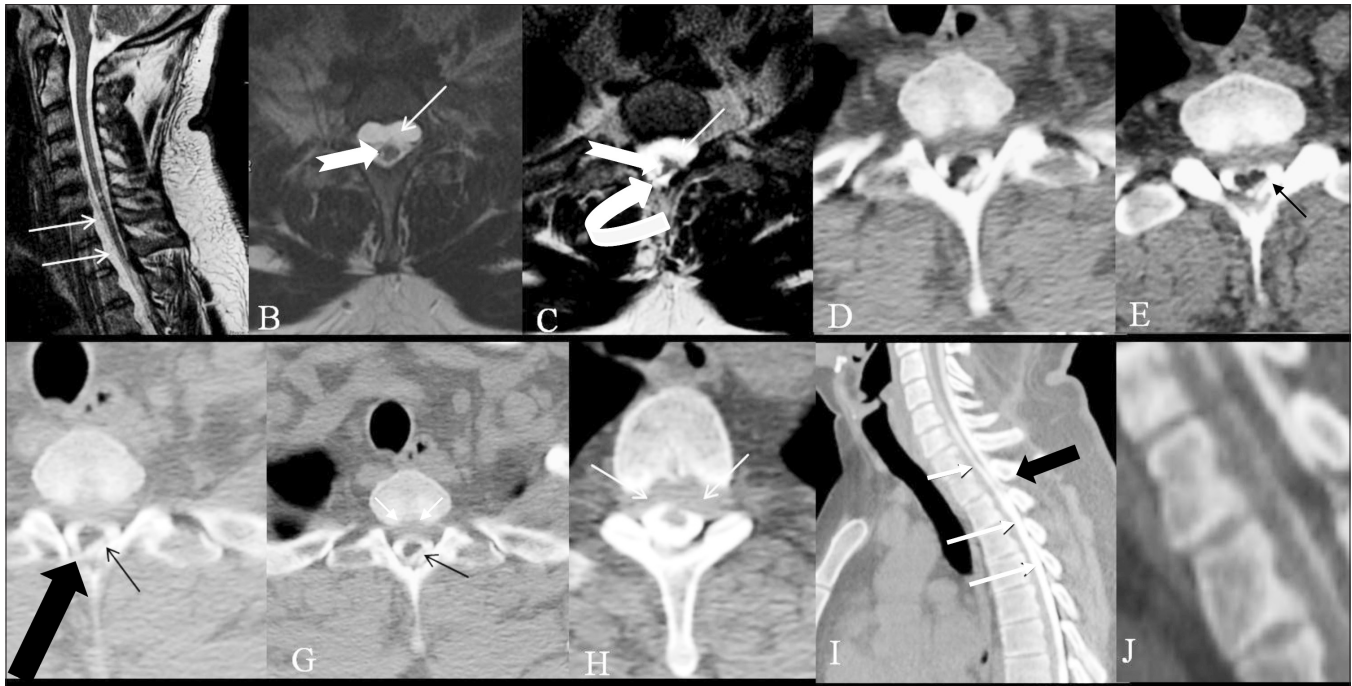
(A-J): Sagittal (A) and axial T2W (B) cervical spinal MRIs demonstrate ventral extradural fluid collection (white arrows) and focal myelomalacia involving the right side of the cord (notched arrow) at the site of the stab injury. Axial T2W images at T1–T2 disc level (C) again demonstrate the ventral fluid collection and the cystic myelomalacia in the right hemicord, with focal right posterolateral tethering of the cord (curved arrow). Serial axial images obtained immediately after lateral decubitus (D), after 1×360° rotation (E), and after 2×360° rotations (F) show right posterolateral leak of contrast (thick black arrows) and left posterolateral fluid collection (E,F) (black arrow). Delayed axial CT myelogram (G,H) show differential opacification of the thoracic ventral fluid collection (white arrows). Sagittal delayed dynamic CT myelogram (I) demonstrates small triangular contrast extravasation posterior to the thecal sac (blue arrows) and differential opacification of the ventral fluid collection (white arrows). Oblique sagittal delayed CT myelogram reformats (J) show contrast leak (thick black arrow)
